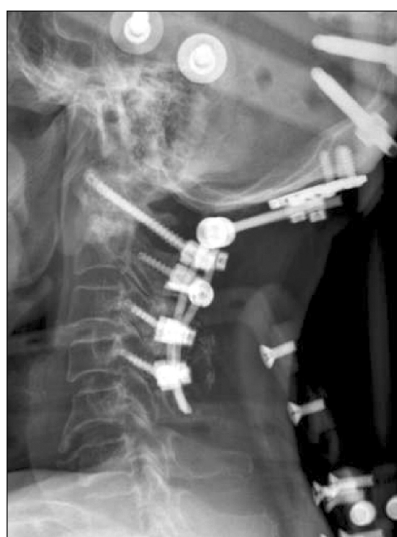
Postoperative lateral plain radiograph of the cervical spine showing posterior occipital-C4 fusion.
